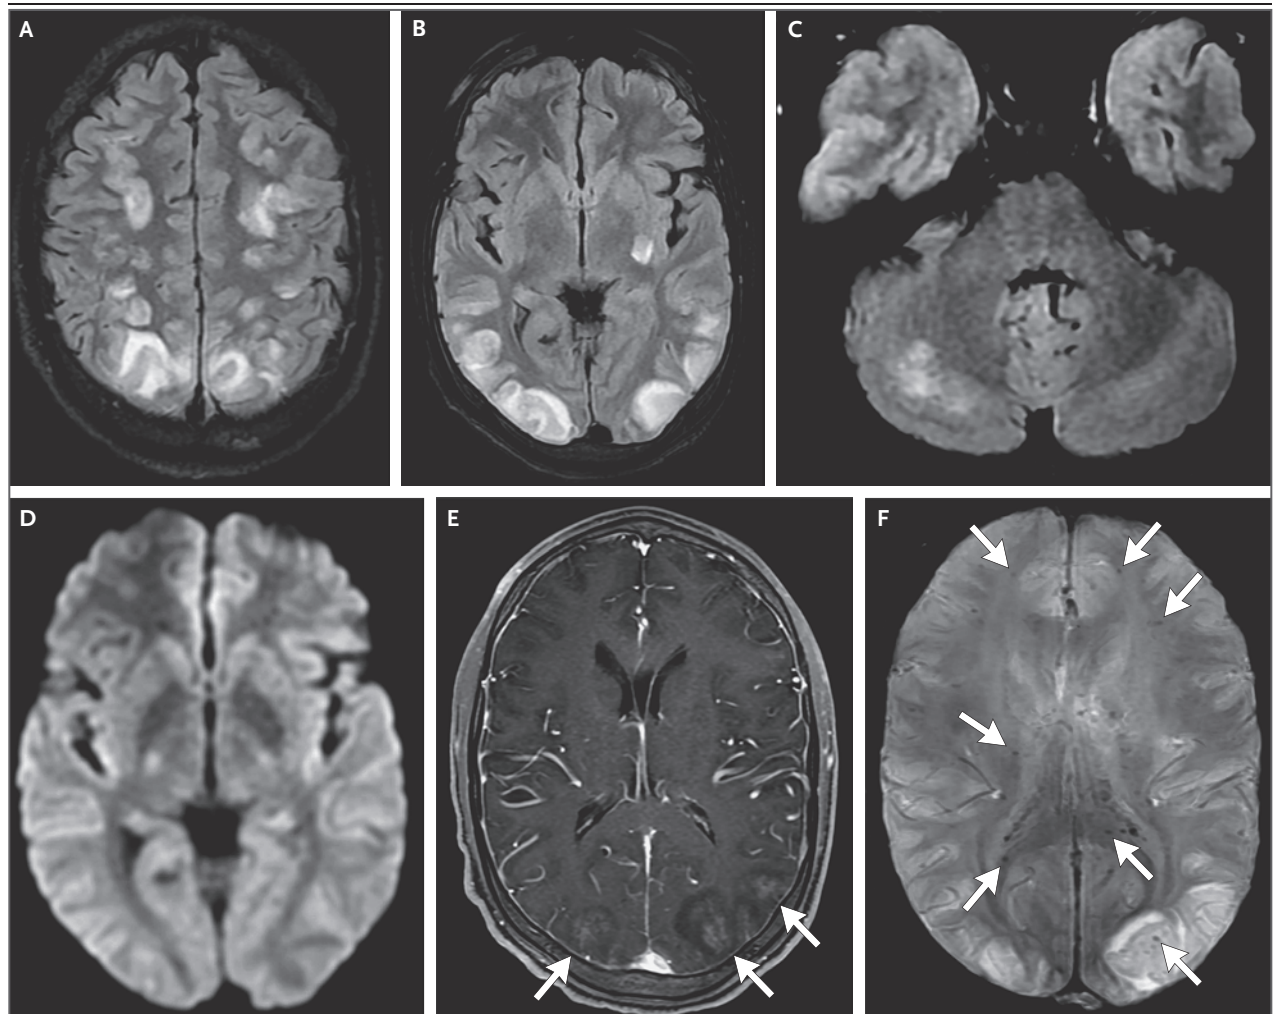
Initial MRI of the Head.
